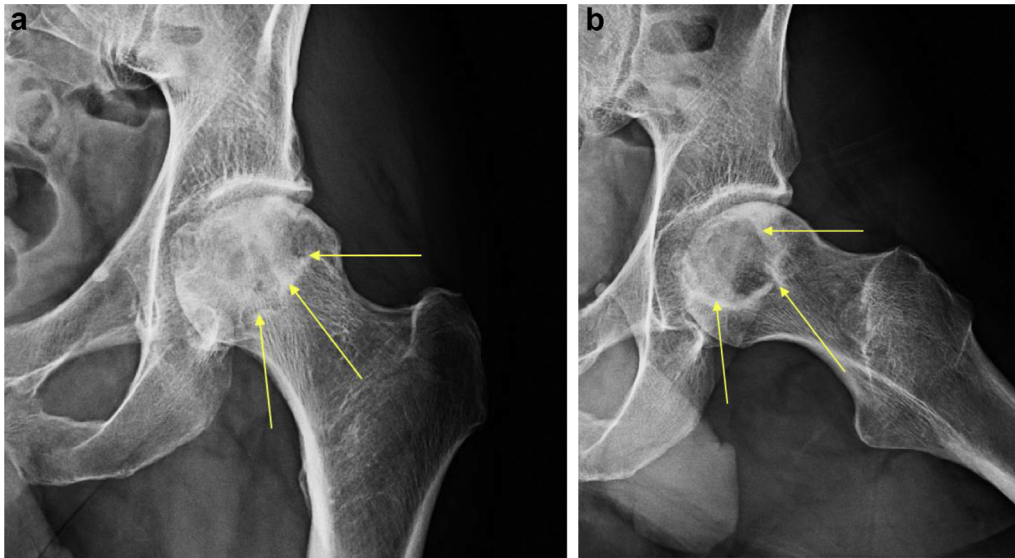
(a) Preoperative anteroposterior (AP) radiograph demonstrating femoral head lesion (arrows). (b) Preoperative frog-lateral radiograph.
